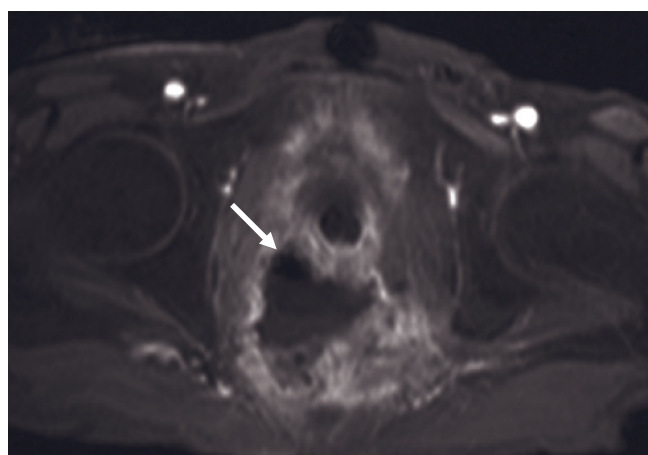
Pelvic abscess. T1-weighted fat-suppressed spin-echo (a), T2-weighted fat-suppressed spin-echo (b), and sagittal gadolinium-enhanced T1-weighted fat-suppressed SGE (c) images in a patient with fever and an elevated white blood cell count. A complex fluid collection (arrowheads, a, b) is demonstrated in the pelvis. The variable signal intensity on the T1-weighted images reflects its protein content (a, c). On the T2-weighted image (b), low-signal-intensity debris layers in the dependent portion of the abscess. A focus of signal-void air is present (arrow, a), which is not uncommonly observed in abscesses. After contrast administration, the wall of the abscess enhances substantially (arrows, c). (bladder = b, b, c). Sagittal (d) and transverse (e) T2-weighted SS-ETSE images in a second patient show a fluid collection in the cul-de-sac that exhibits layering of low-signal material on T2-weighted images (arrows, d, e), consistent with abscess. A lesser volume of nonoculated fluid is also observed around the uterus.
